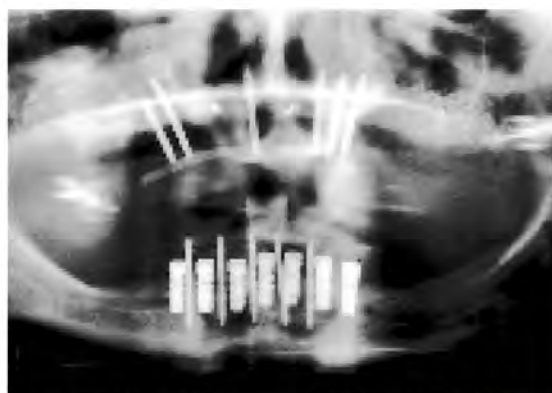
Postoperative panoramic radiograph after initial surgical procedure.
